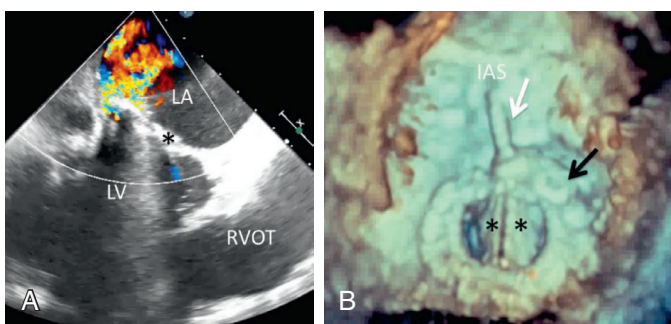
■ Severe paravalvular leak in a 72-year-old male with a history of multiple mitral valve (MV) replacements due to previous endocarditis presenting with symptomatic heart failure and hemolytic anemia. Two-dimensional transesophageal color Doppler (A) shows eccentric regurgitation around the closed prosthetic MV occluder (*) during systole. Three-dimensional echocardiography (B) assists with paravalvular closure of the defect using an Amplatzer plug (*black arrow*). A second plug is required in this case and can be seen being deployed via a transseptal catheter (*white arrow*) during diastole with an open MV occluder. IAS, interatrial septum; LA, left atrium; LV, left ventricle; RVOT, right ventricular outflow tract.
